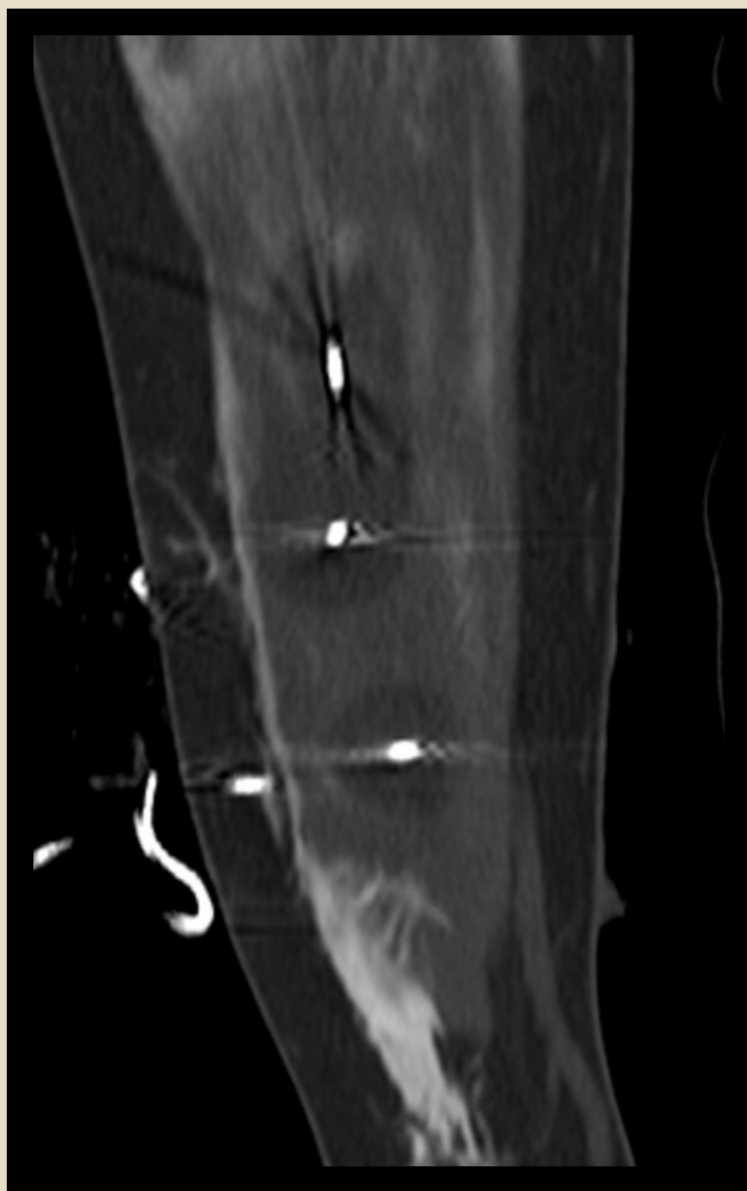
Intra-procedural CT demonstrating cryotherapy probes in desmoid fibromatosis with surround ‘ice ball’ formation
